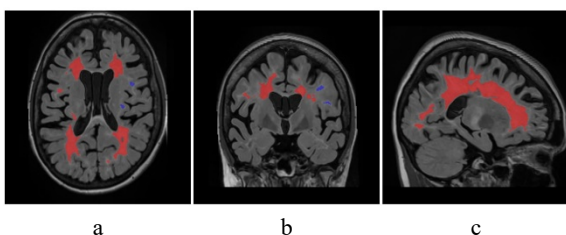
(a - axial, b - coronal, c - sagittal coronal). The results of MRI morphometry of the lesions of 42 y.o. female patient after HDIT + AHSCT. Red colour indicates MS lesions.
